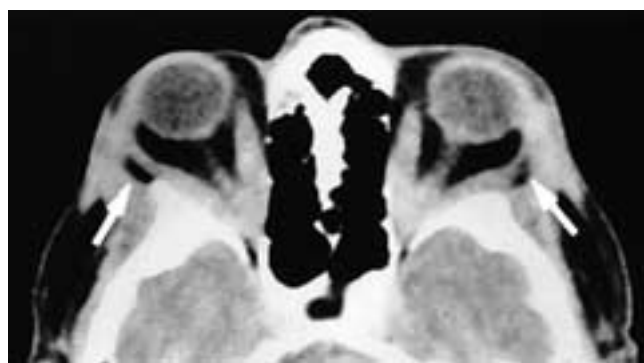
Axial CT scan shows a patient with the changes of thyroid ophthalmopathy. All of the extraocular muscle bellies are enlarged, and there is tapering at the tendon insertions. There is also bilateral proptosis. The lateral orbital walls (*arrows*) have been surgically removed, making the proptosis appear even greater than it is. This patient has had bilateral lateral orbitotomies (Krönlein's approaches).
